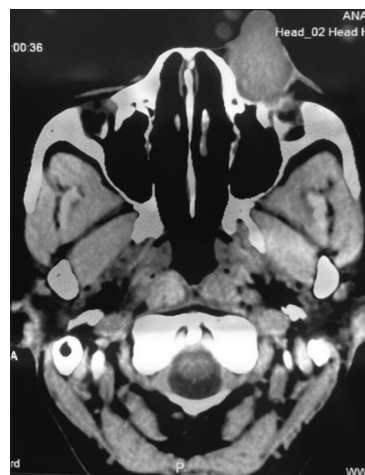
Axial computed tomography scan showing a large exophytic mass without bony erosion.
